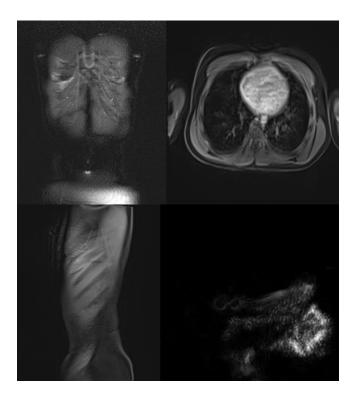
MRI and MRCP Imaging
